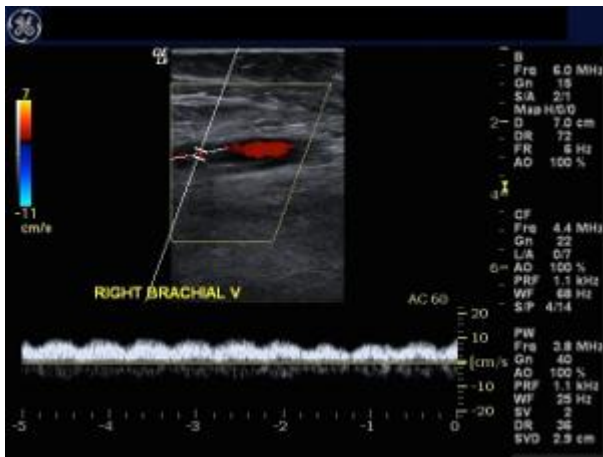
Color and Spectral Doppler image of Right Brachial Vein
